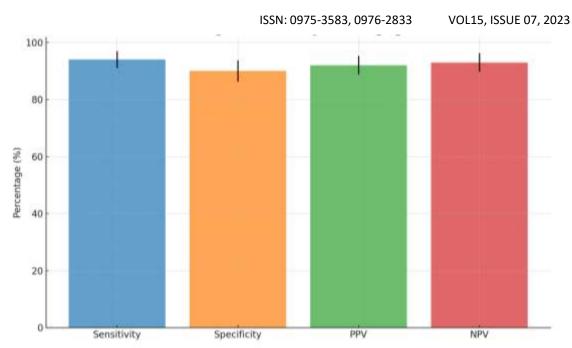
Figure No:2. Diagnostic Accuracy -CT Imaging
